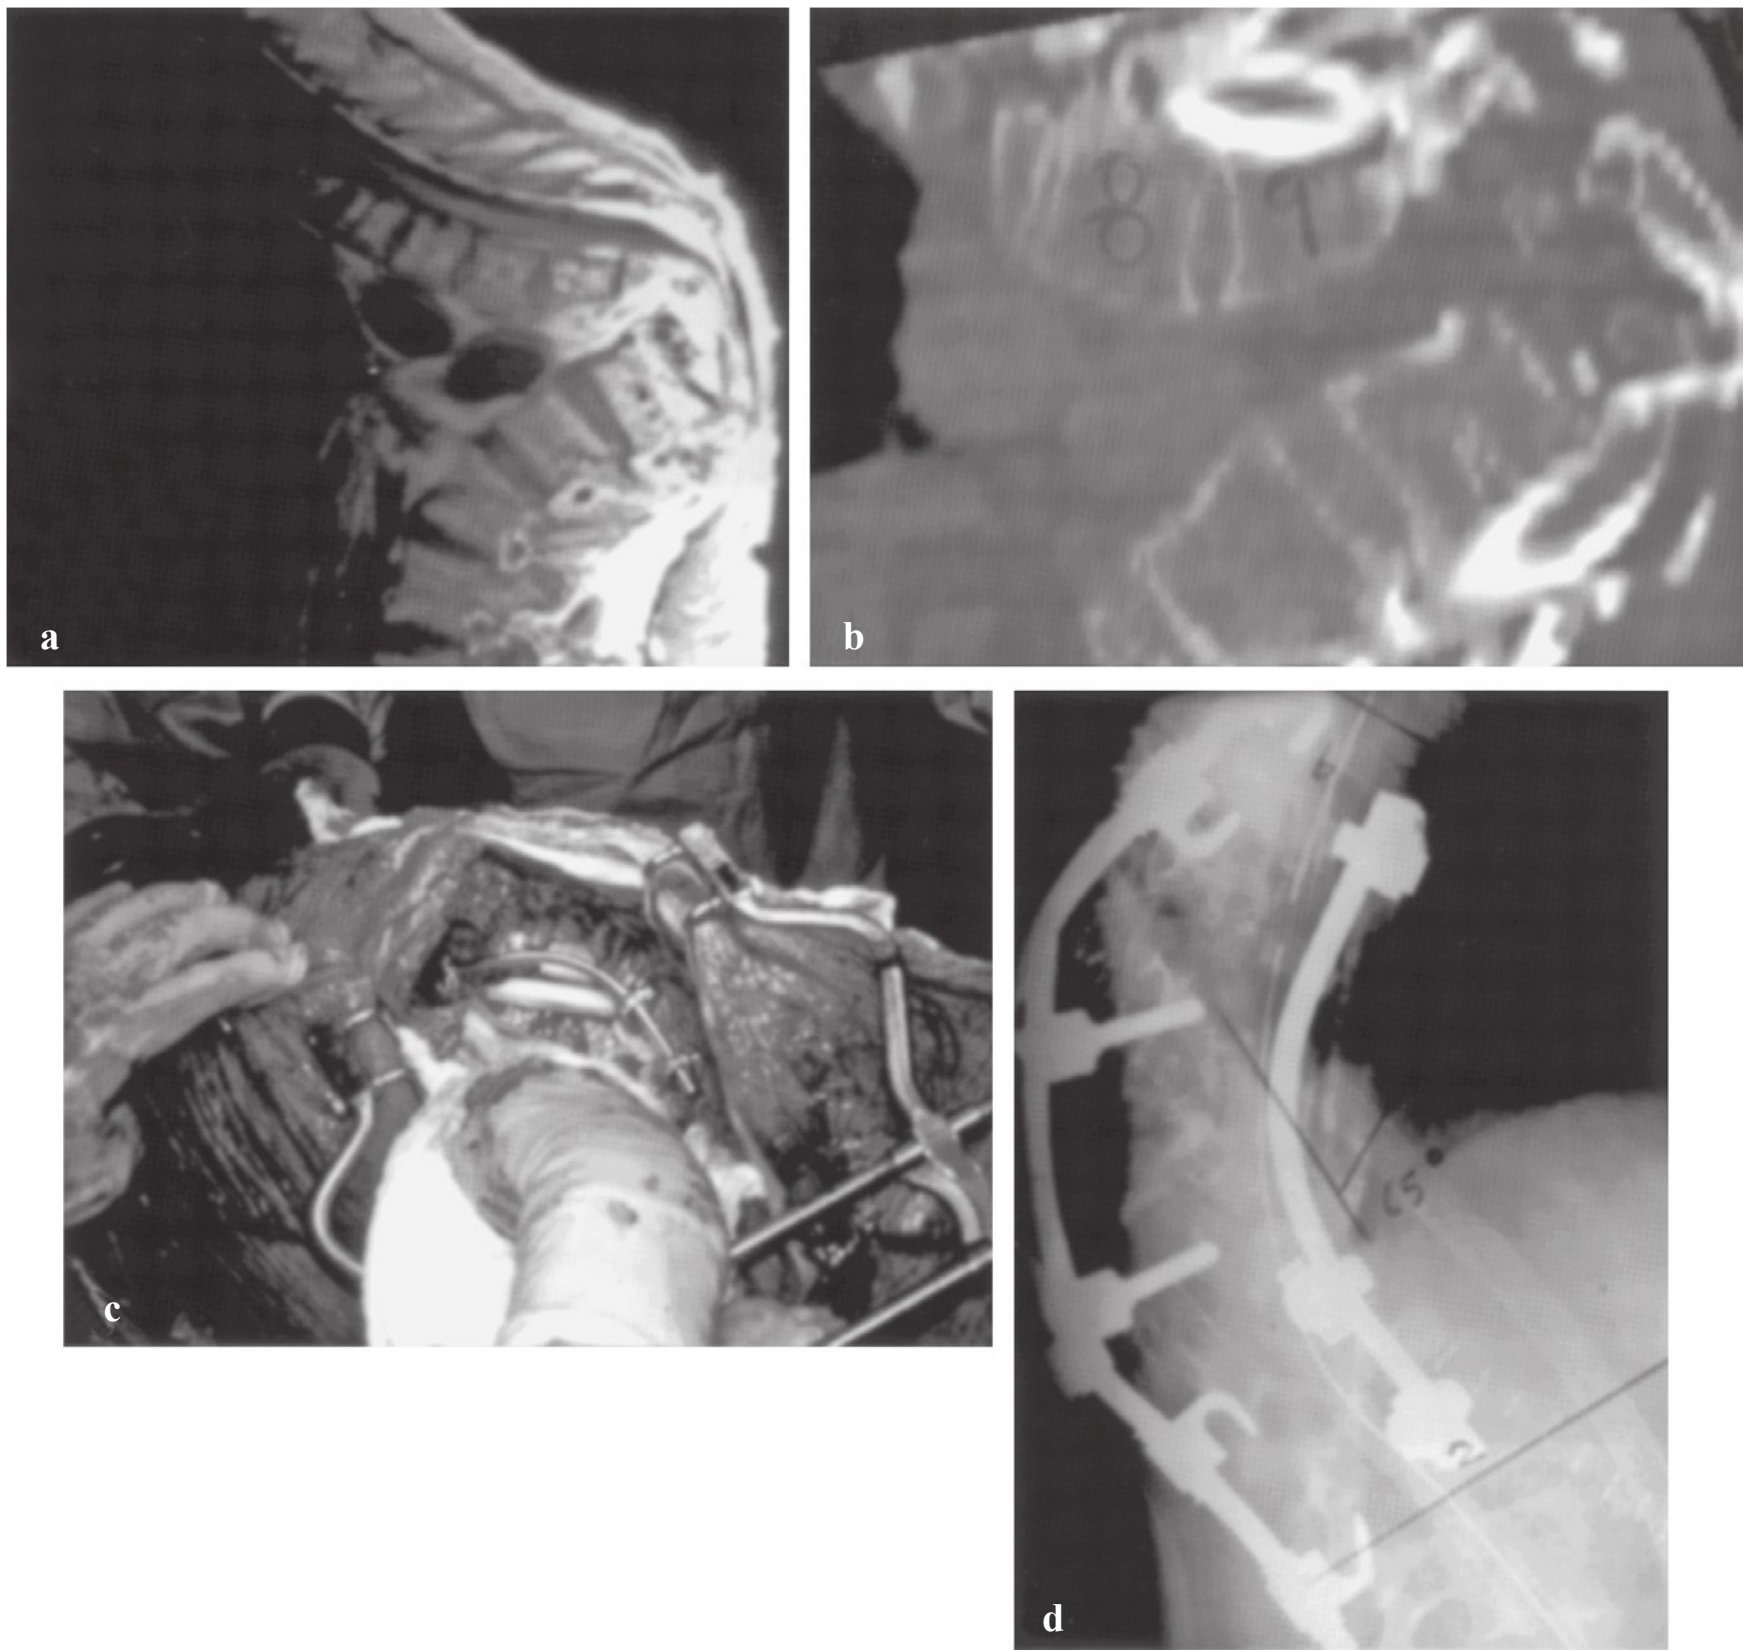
Images of a 44-year-old man with neurofibromatosis who presented with severe kyphoscoliosis and paraplegia. A simultaneous anterior and posterior approach was performed on this patient to combine anterior and posterior procedures. The steps of the procedures included a posterior osteotomy, anterior vertebrectomy, spinal cord decompression, anterior fusion with strut grafting, posterior compression instrumentation, and anterior instrumentation, in this order. (a) Preoperative magnetic resonance image showing 170° kyphosis with cord compression. (b) Computed tomographic (CT) myelogram demonstrating severe kyphotic deformity with signal cutoff distal to the T9 vertebra. (c) Intraoperative photograph showing anterior vertebrectomy, fibular strut graft, and anterior instrumentation. (d) Postoperative radiograph showing 65° of kyphosis.
